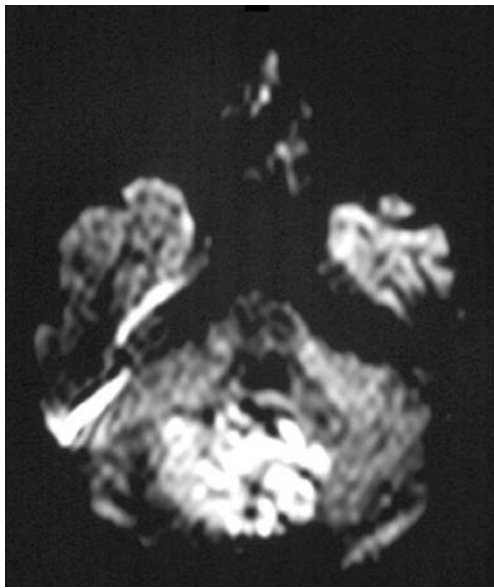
Axial MRI (DWI) hyperintensity of some tumour areas, indicating decreased water proton diffusion as seen in keratin-rich lesions (Patient 4)
